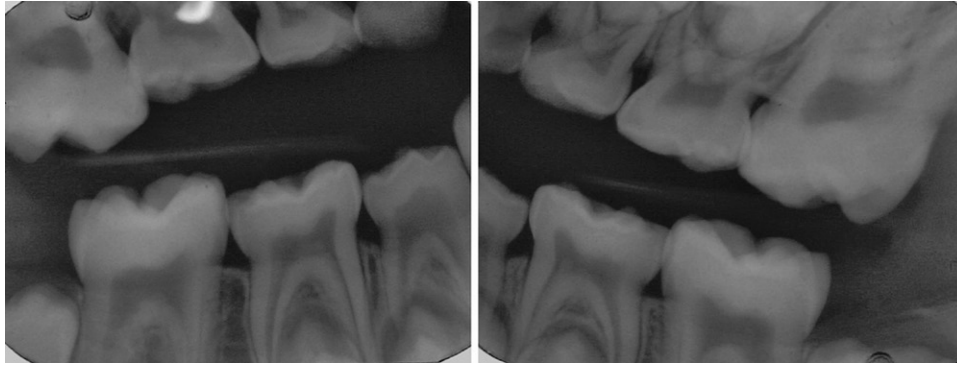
Radiographic presentations of patient HN at eight years of age with vitamin D deficiency.
